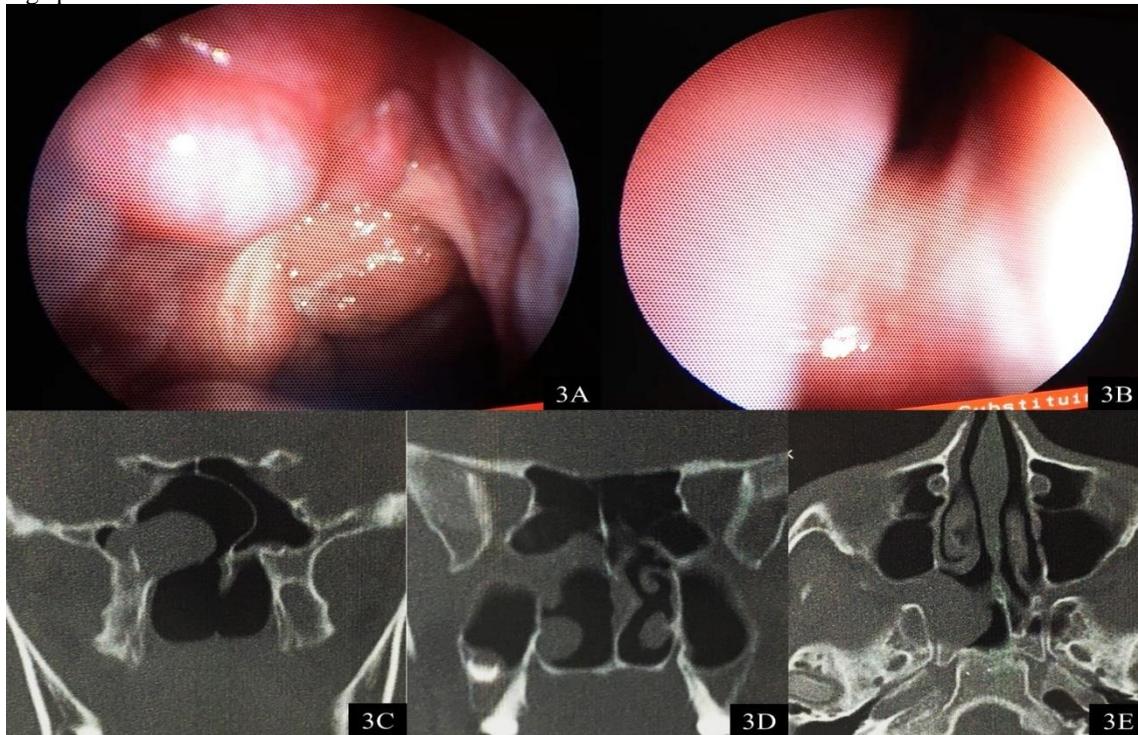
Nasopharyngeal angiofibroma. (3A-3B) Nasal endoscopy showing non-friable exophytic lesion with hyperemic mucous cover, posterior to right middle turbinate, emerging from sphenoid rostrum on the right and obstruction of superior nasal meatus without visualization of superior nasal concha. Post-operative CT scan of the paranasal sinuses in bone window: (3C) coronal section showing soft tissue density lesion entering the right sphenoid sinus; (3D) coronal section with the same lesion also affecting right maxillary sinus and invading inferior orbital fissure; (3E) axial section showing enlargement of pterygopalatine fossa and sphenopalatine foramen by the lesion, entering sphenoid sinus.
